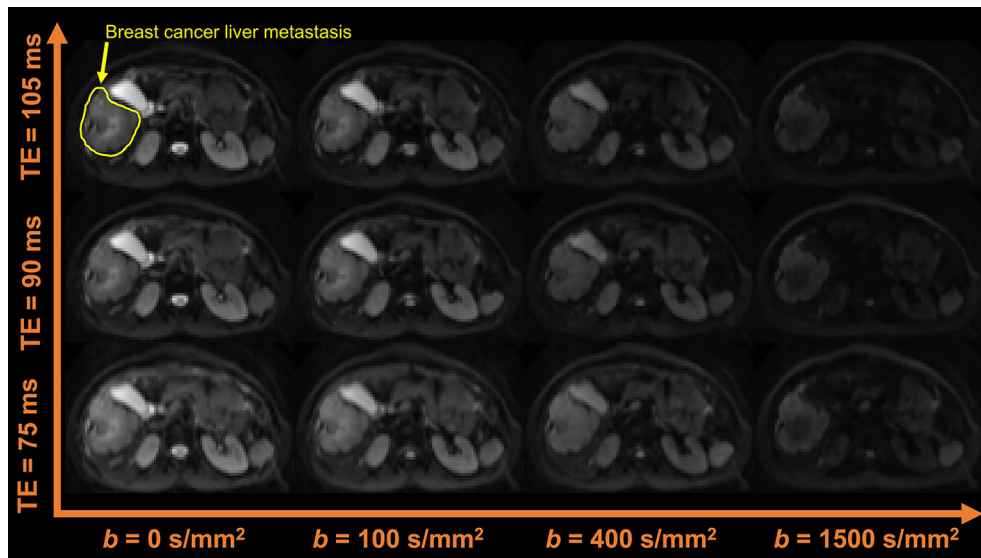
Example of a rich, advanced DW-MRI acquisition in body cancer. The figure shows a diffusion-relaxation acquisition performed at the level of the abdomen with a 3 T system, to image a breast cancer liver metastasis. The diffusion protocol features the acquisitions of multiple  $b$ -values  $b$  with LTE, each acquired independently at several echo times TE.
